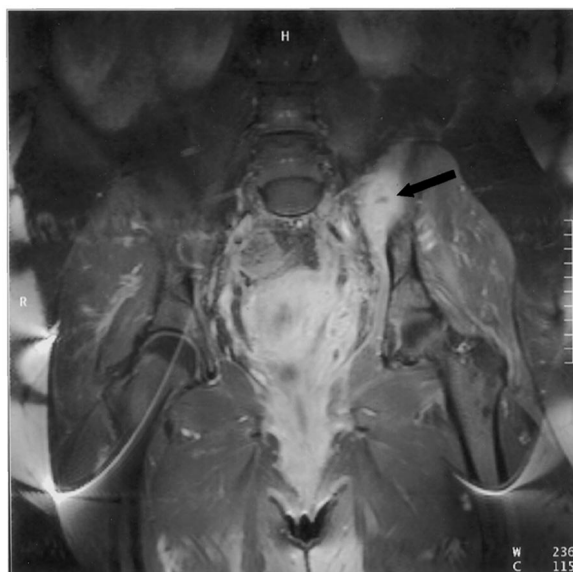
Magnetic resonance imaging: postcontrast T-1 weighted image showing inflammatory thrombophlebitis surrounding clot in left ovarian vein. Inflammation extends to the area of the left sacroiliac joint (arrow).
